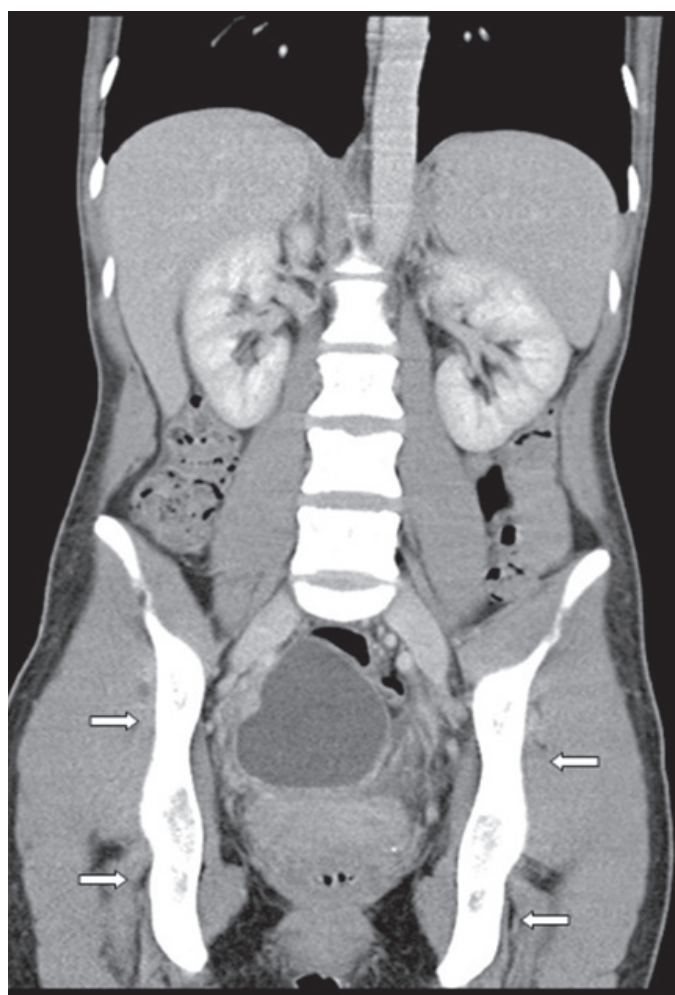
Coronal computed tomography scan of patient, upon admission to hospital. Infection has spread bilaterally in the ovaries and large areas of the pelvis.
